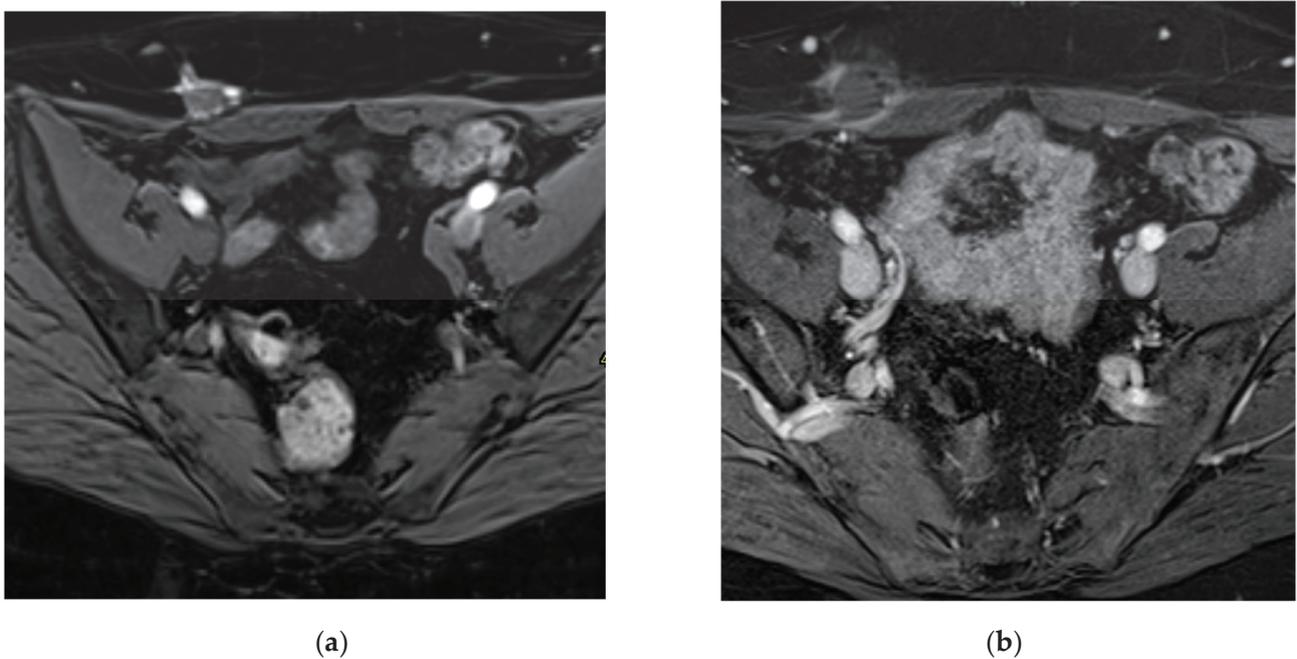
Pre- (a) and post-cryoablation (b) MRI, contrast-enhanced T1 FS WI. On post-treatment MRI, we can notice the full coverage of the AWE lesion and an inflammatory rim enhancement, corresponding to a good imaging and clinical outcome.
